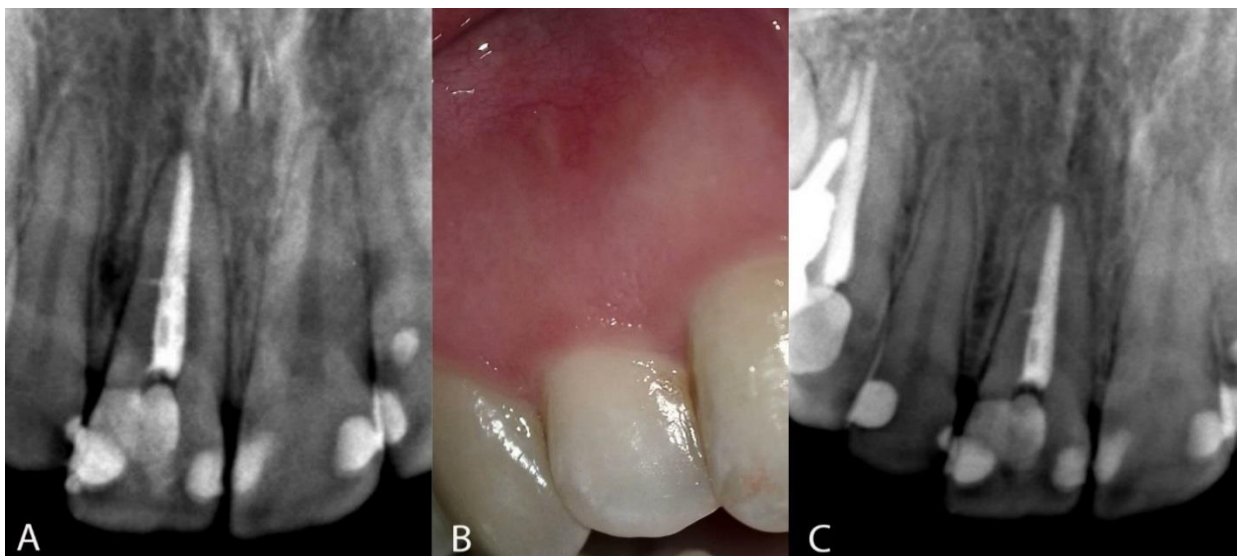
A) No periapical pathosis could be detected in the apical area of right maxillary central incisor; B) Four years follow-up photography showed the sinus tract was healed; C) Four years follow-up radiograph showed that the radiolucency was healed
